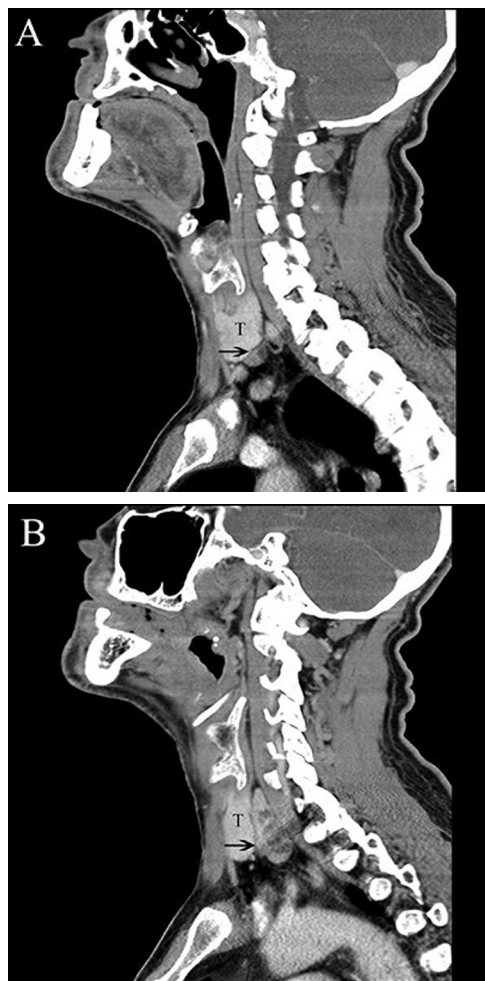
Sagittal images from three-dimensional CT scans show a clear line demarcating bilateral parathyroid adenomas (black arrows) on the right (A) and on the left (B) separating them from the thyroid gland (T).
